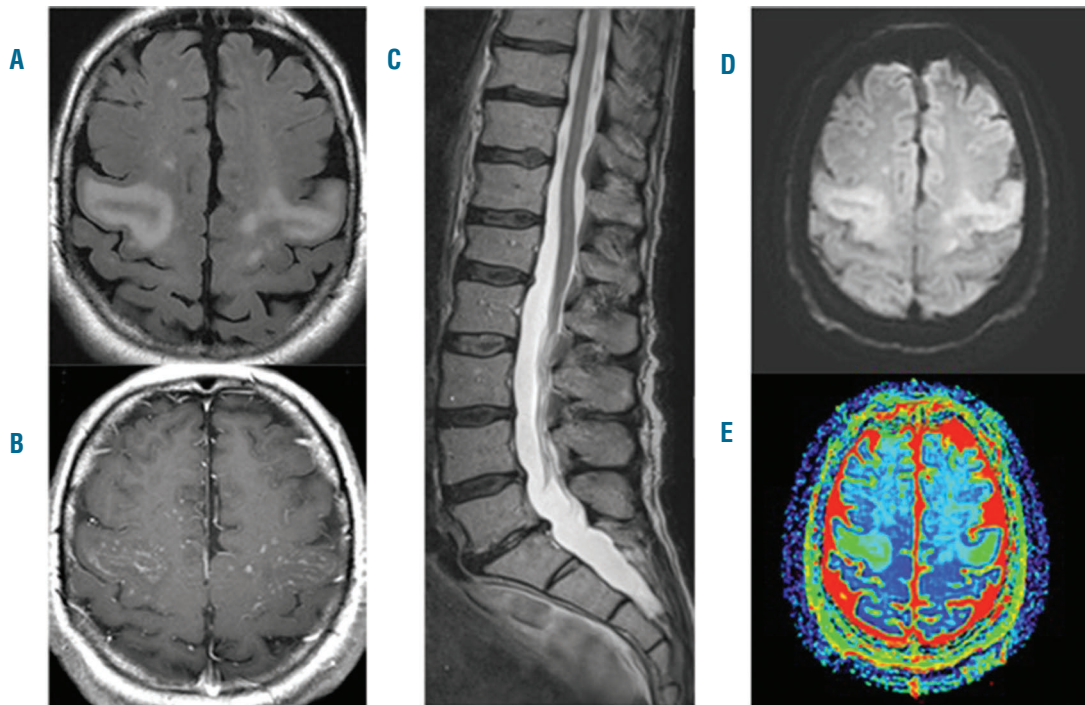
MRI abnormalities in BNS. A. Parenchymal involvement of the brain, increased signal abnormalities in both pre-central regions in axial FLAIR sequence. B. Brain parenchymal involvement, multiple nodular contrast enhancement in both pre-central regions in axial T1 sequence after contrast media administration. C. Cauda equina thickening T2 sagittal sequence. D. Positive diffusion showing high signal in both pre-central regions. E. ADC map reconstruction showing high signal in both pre-central regions.
